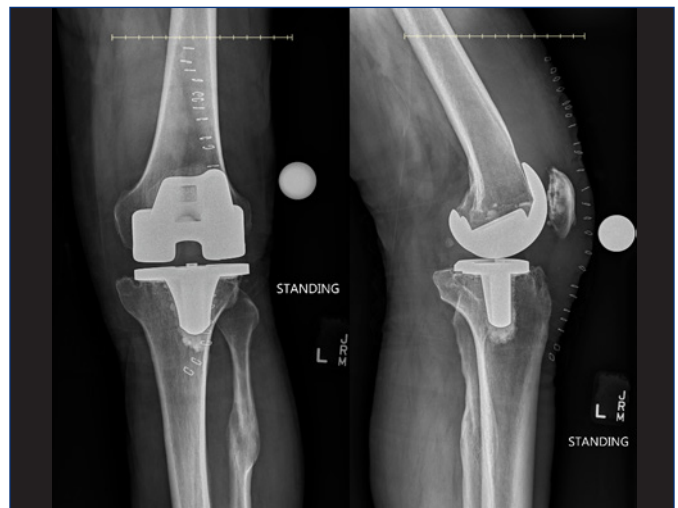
Post-operative plain radiographs of the left knee AP (left) and lateral (right) views showing stable alignment after polyethylene exchange.
